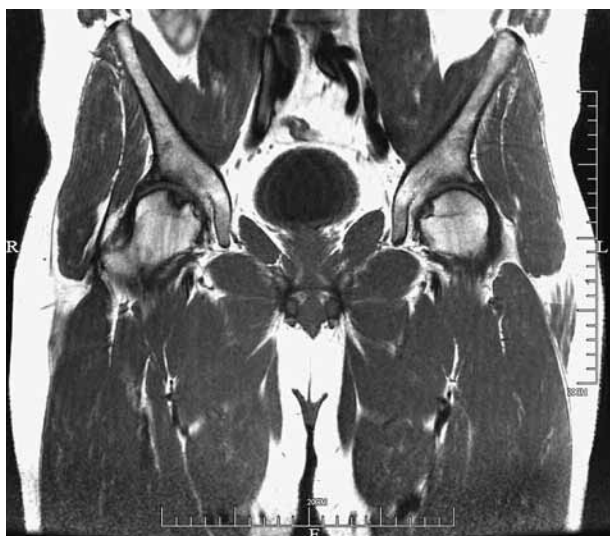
Pre-operative MRI of the pelvis, coronal view. Osteochondral lesion of the right femoral head clearly visible as a defect on the articular side.
